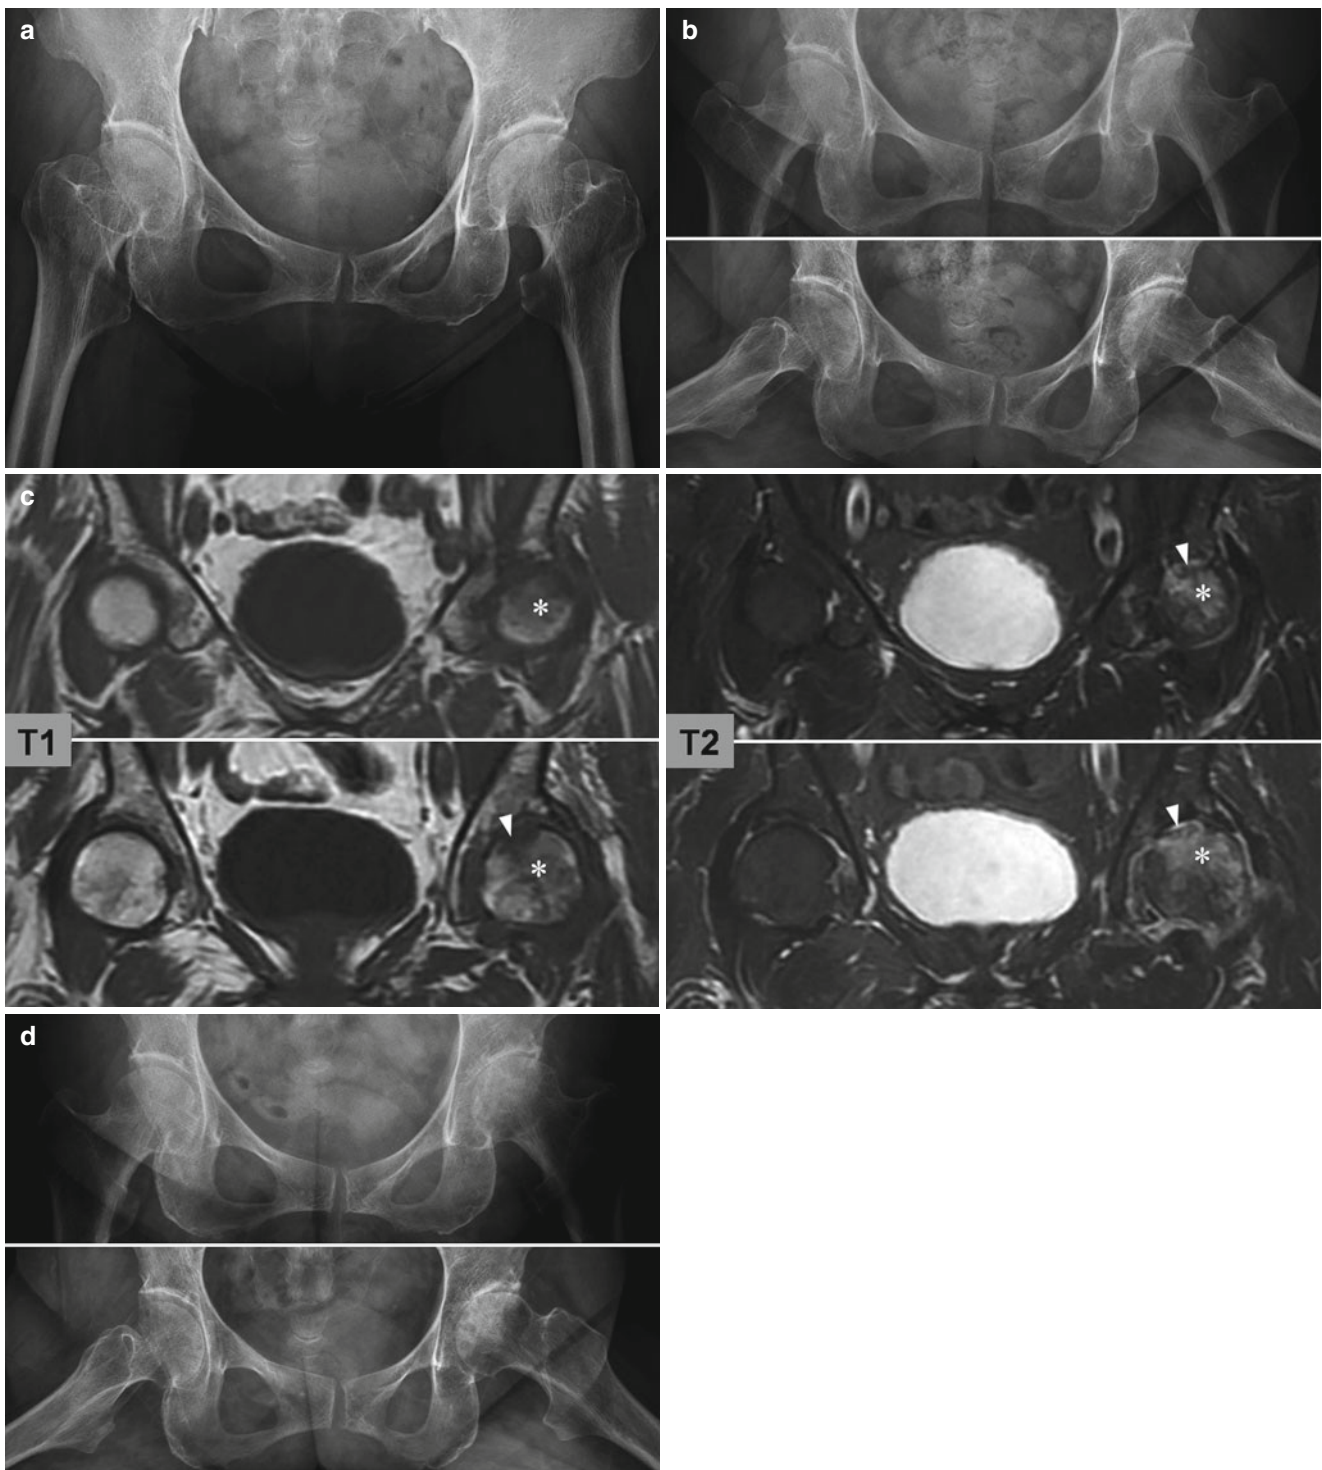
A 65-year-old woman with insufficiency-type subchondral stress fracture of the femoral head. (a) Plain radiograph taken 2 months before the onset of left hip pain shows no remarkable abnormalities. (b) Radiographs taken 2 months after the onset of the left hip pain show joint space narrowing of the left hip without any other bony abnormality.
